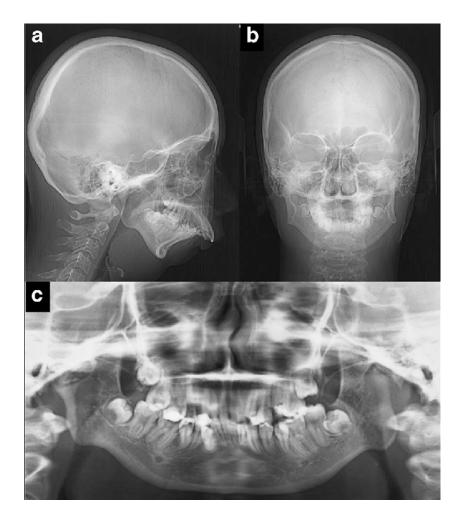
Radiographic picture of bilateral ankylosis; (a) lateral cephalogram, (b) skull P-A, (c) OPG.
